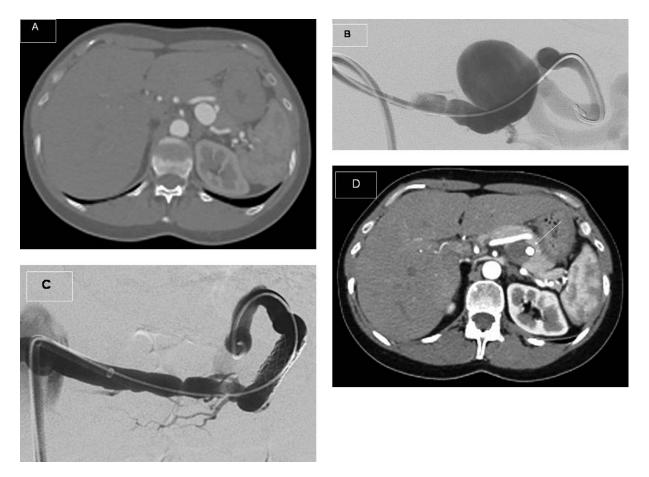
A, Computed tomography angiography (CTA) demonstrates a 2.6 cm splenic artery aneurysm. B, Angiogram of splenic artery aneurysm before stent deployment. C, Angiogram of splenic artery aneurysm after stent-graft deployment. D, Postoperative CTA demonstrating aneurysm exclusion by stent-graft (arrow). Heterogeneity of splenic tissue represents differences in flow dynamics between arterial supply and venous sinusoids.
